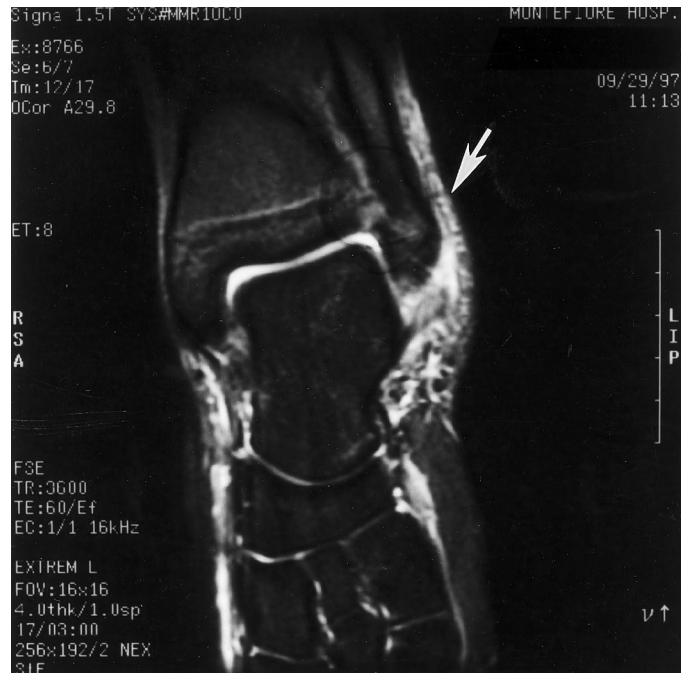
MRI taken 3 days after the injury does not conclusively show any damage to the peroneal retinaculum. However, effusion lateral to the fibula is seen.
